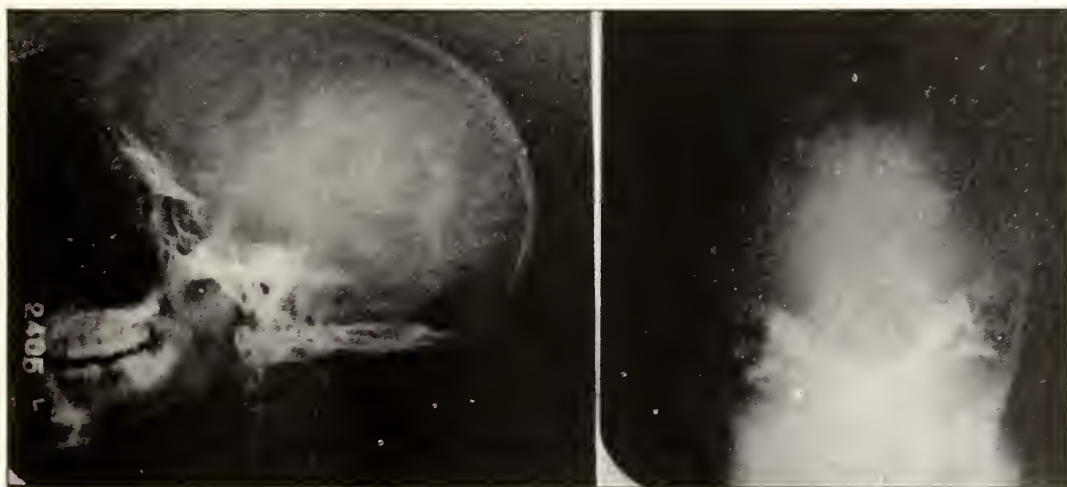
Lateral radiograph and "occipital projection" of the skull. On the lateral view, note the flat appearance of the occipital bone. The odontoid process is above a line drawn from the posterior lip of the foramen magnum to the hard palate. This is pathognomonic of platybasia. On the "occipital projection" one can note a large foramen magnum and the posterior arch defect in the atlas.
